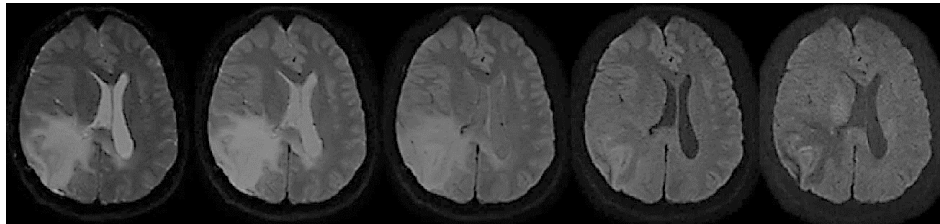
DWI axial brain images for 5 b values from left to right, $b = 0, b = 200, b = 500, b = 1000, b = 2000$ $[\frac{s}{mm^2}]$.
